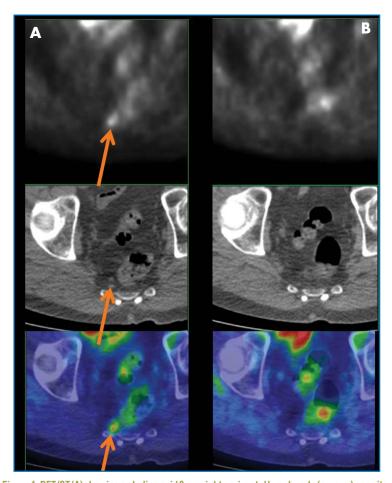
PET/CT(A) showing a choline avid 3mm right perirectal lymph node (arrows) as a site of disease (CT biopsy-proven) in a patient with prostate cancer recurrence (PSA 0.92) with two other small choline avid nodes (not shown) and a PET/CT5 months later (B) after androgen deprivation therapy showing resolution of choline uptake (PSA < 0.01). Systemic therapy rather than prostate bed irradiation was chosen based on PET findings.
